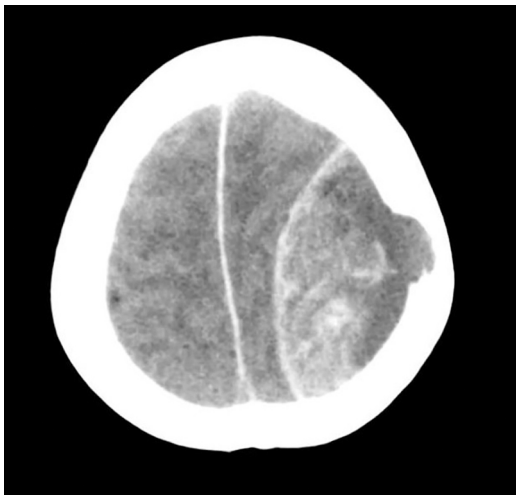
Head CT: left-sided frontoparietal acute epidural haematoma. Osteolytic cranial vault lesion of a probable metastatic aetiology.
